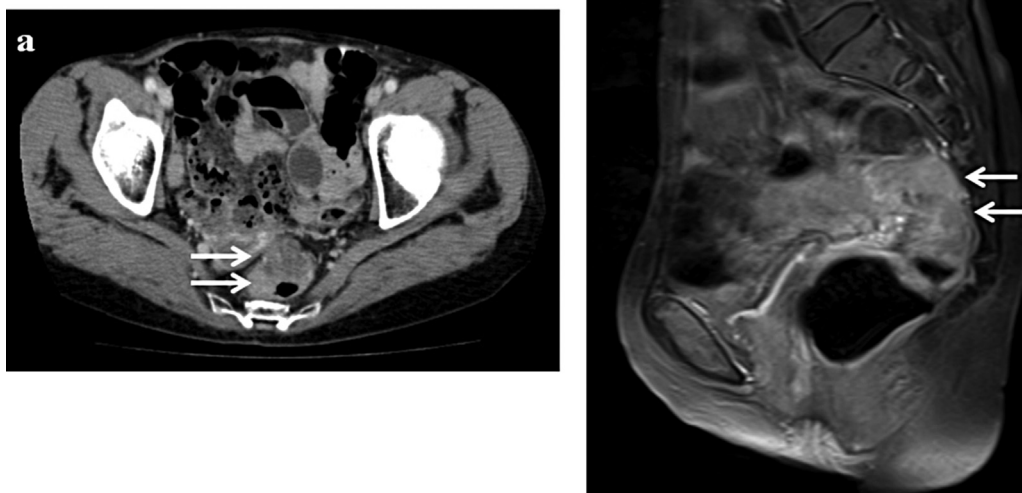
Abdominal computed tomography examination showed enhanced wall thickness of the rectum with no suspicion of invasion of the surrounding organs (arrow). There was no sign of swelling of the lymph nodes in the mesorectum (a). Pelvic magnetic resonance imaging (T1 weighted image) showed a heterogeneous intensity mass of the rectum, with no suspicious uterus or sacrum (b).
